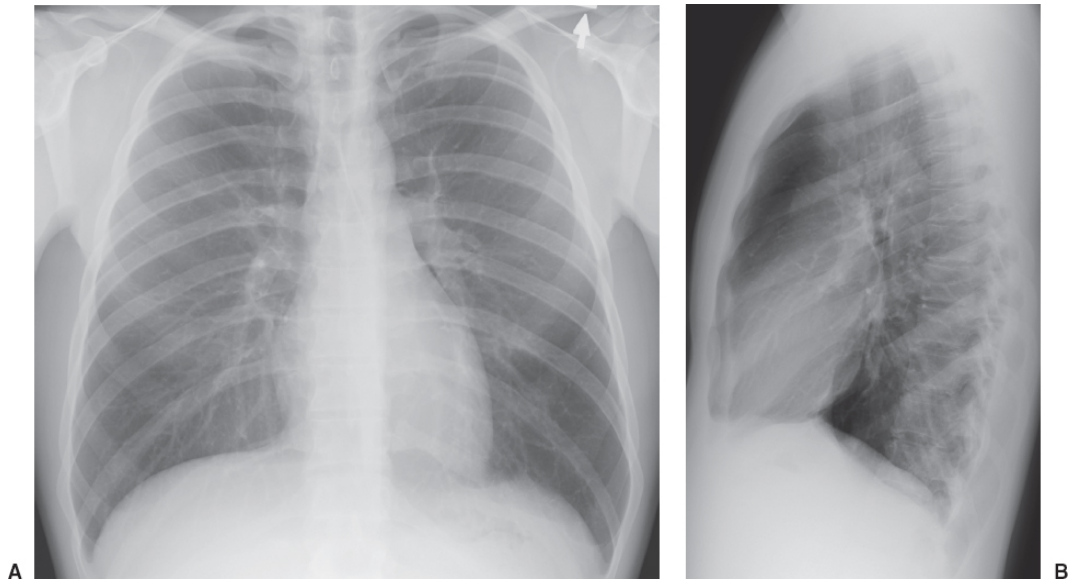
Normal posteroanterior (A) and lateral (B) chest radiographs. (From Collins J, Stern EJ. *Chest Radiology: The Essentials*. 3rd ed. Wolters Kluwer; 2015, Fig. 1-2ab.)
